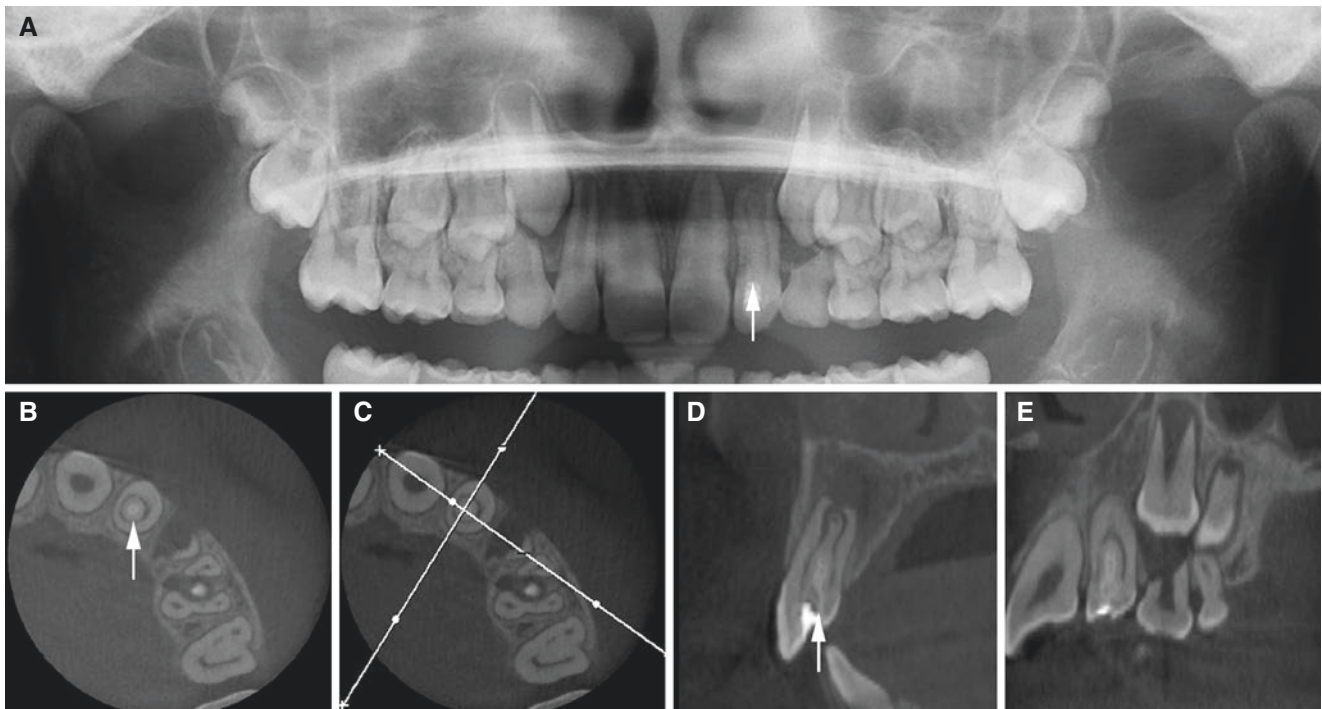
Enamel invagination (dens invaginatus), lateral incisor, maxilla; 10-year-old male. (A) Panoramic view and (B) axial, (C) axial (with cursor lines), (D) oblique sagittal, and (E) oblique coronal CBCT
